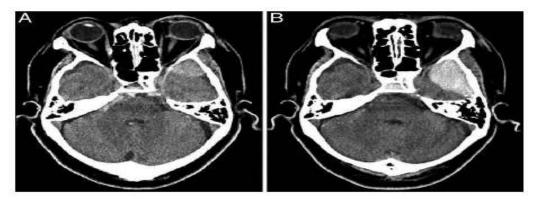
A case in which deterioration of a temporal tip EDH showed (A)Admission head CT scan obtained in a 51-year-old man revealing a temporal tip EDH measuring 20 mm in thickness, and opacified ethmoidal sinuses.(B) 6 hrs later, the hematoma was found to have increased in size, and it was therefore surgically evacuated ⁽¹⁹⁾.
